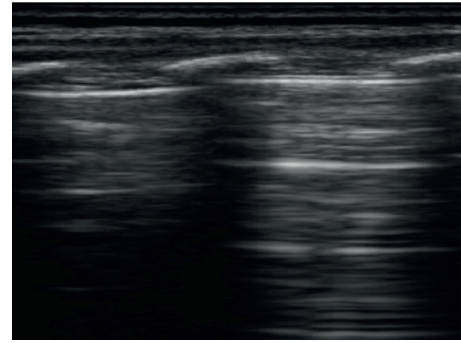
The lung B-ultrasound image of one subject in the control group. Note: the line A was smooth and visible.
